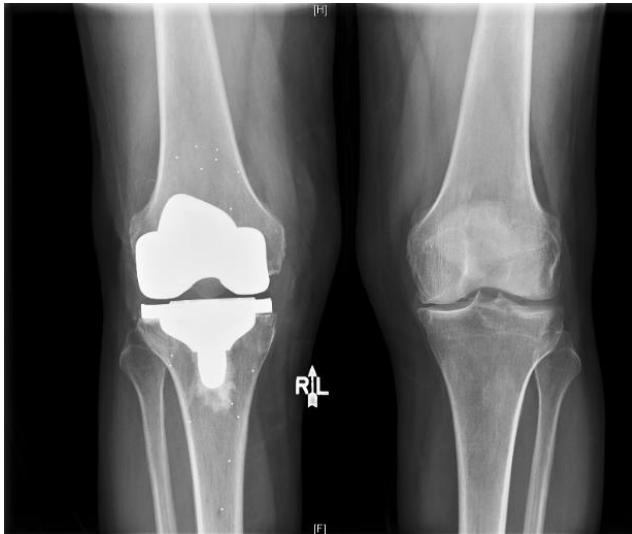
An AP radiograph of both knees after a right TKA with tantalum bead implantation according to a standard protocol with 8 beads in the femur and 8 beads in the tibia.
